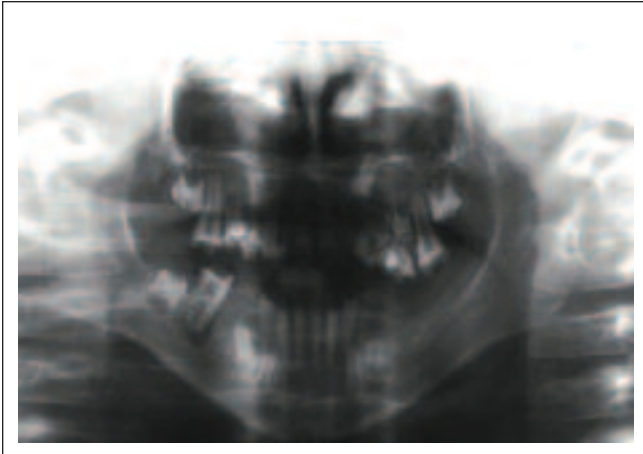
Panoramic radiograph revealed hypodontia, taurodontism in permanent right mandibular first molar and reduced enamel layer on the crown of the all teeth.
